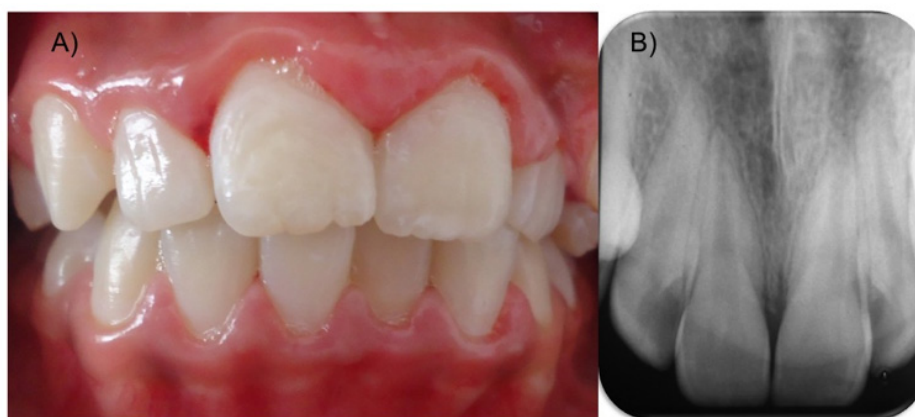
Final clinical and radiographic outcomes after 12 months of orthodontic treatment. (A) Final intraoral photograph showing complete closure of the maxillary midline diastema and satisfactory alignment of the maxillary central incisors. (B) Periapical radiograph showing the final position and root alignment of the maxillary central incisors.
